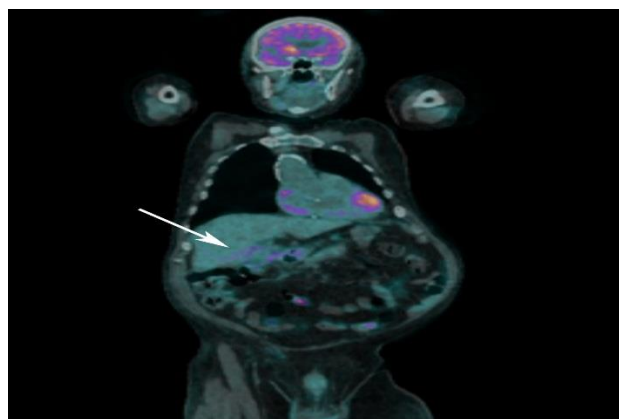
Positron emission tomography (PET) scan, coronal view, taken 10 days post-operatively demonstrating increased fluoro-deoxyglucose (FDG) uptake in the gallbladder fossa (arrow).
